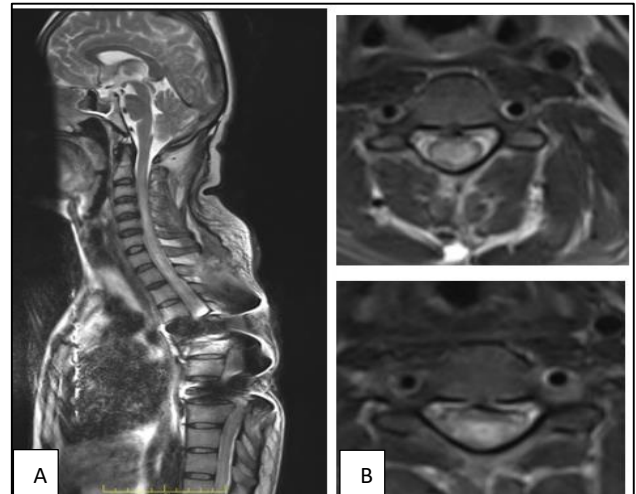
(A and B): Cord myelomalacic changes above the level of fixation seen at 4 weeks post operatively ascending till C3. Sagittal section and axial section of the post operative T2-weighted MRI taken after admission. Postoperative changes can be appreciated at the T3-T6 level of the thoracic cord.
